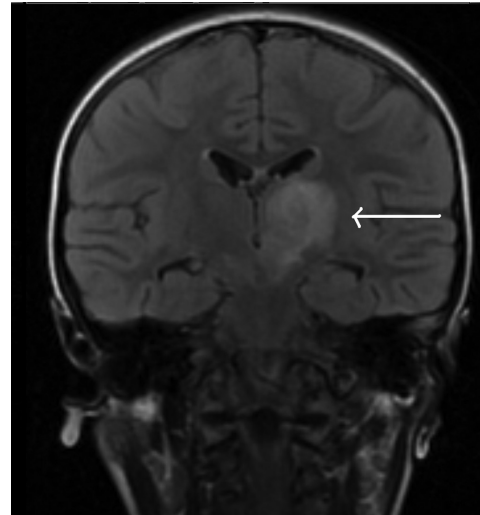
MRI of the patient shows an ischemic-hemorrhagic infarction of left thalamus and mesencephalon (marked by the arrow) (on coronal T2-weight image).
